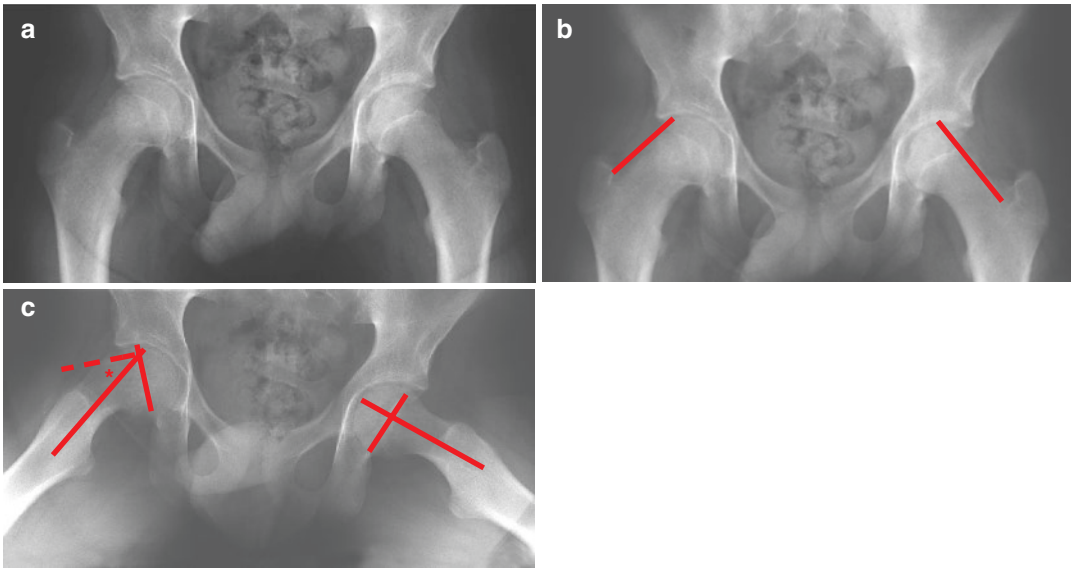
(a) Anteroposterior X-ray of the pelvis with a right-sided slipped capital femoral epiphysis. This is difficult to recognize on an anteroposterior image when the slippage is mild. (b) To detect slippage on an anteroposterior X-ray of the pelvis, the Klein line can be drawn along the upper edge of the femoral neck. If this line does not go through the femoral head (*Trethowan sign*), as is the case
